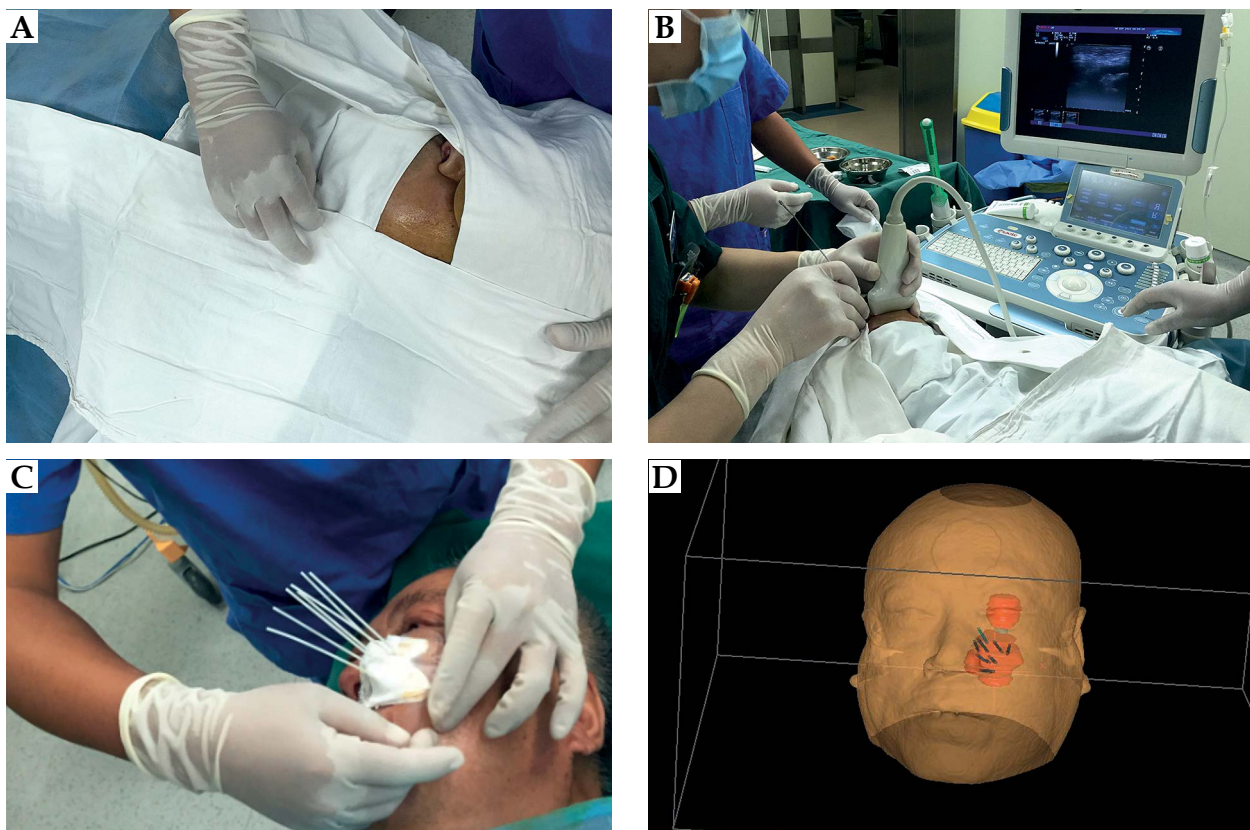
Eight applicator catheters inserted to the target under ultrasound guidance (A, B, C) and reconstructed with three-dimensional mode (D)
